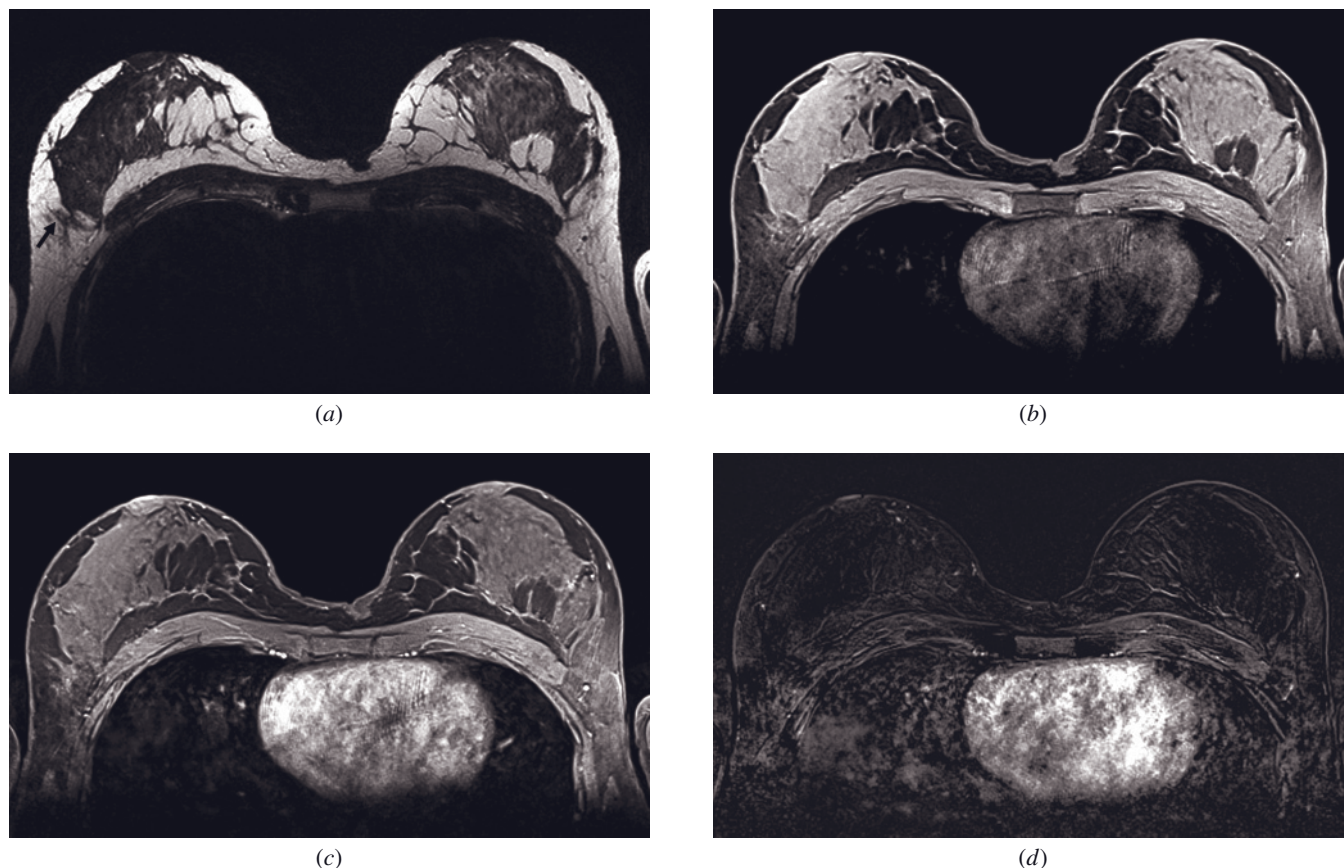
Normal anatomy of the breast. The exquisite image quality in depicting the entire breast anatomy was possible with the 3T MRI unit with the 8-channel dedicated breast coil. Axial T2-weighted (*a*) and 3D gradient echo with fat suppression [volume imaging with enhanced water signal (VIEWS)] (*b*) images show normal breast anatomy. Fibroglandular tissue appears as dark, hypointense signal, and fat is shown as bright, hyperintense signal on T2-weighted image. 3D gradient recalled echo (GRE) images show hyperintense fibroglandular tissue and low-intensity fat tissue. On postcontrast GRE (*c*) and subtracted (*d*) images, there is no significant increase in signal enhancement of the breast tissue, indicating MRI background enhancement type 1. Note the small amount of T2-weighted hypointense scar tissue in the upper outer quadrant of the right breast (arrow, *a*), as a consequence of prior benign surgery.
